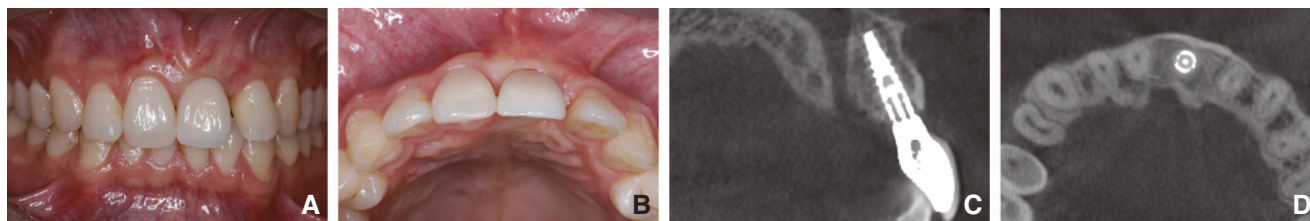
Three-year postoperative follow-up. A, Frontal image. B, Occlusal view. C, D, Sagittal and axial cone beam computed tomography images.
